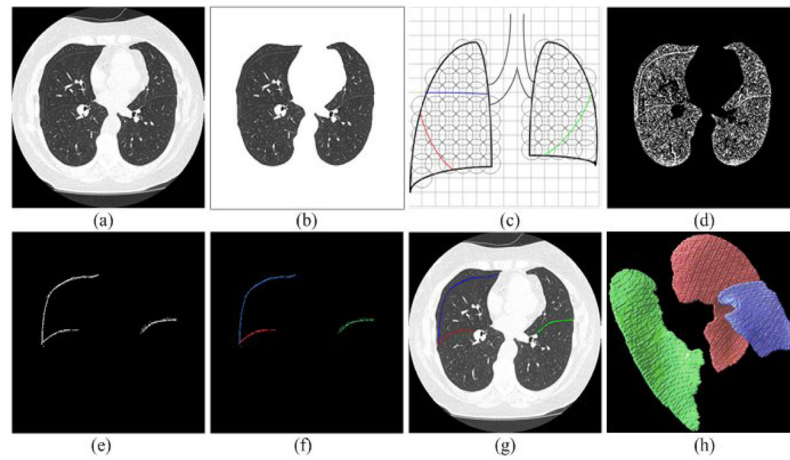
Basic steps of the pulmonary fissure segmentation scheme: (a) a chest CT examination, (b) the segmented lung volume of (a), (c) the subdivision of the segmented lung volume, (d) application of a point filtering, (e) fissure detection after application of the analytical plane fitting algorithm, (f) the clustered types of fissures, (g) identified fissures displayed as overlay, and (h) the 3D surface model of the detected fissures in (g).
